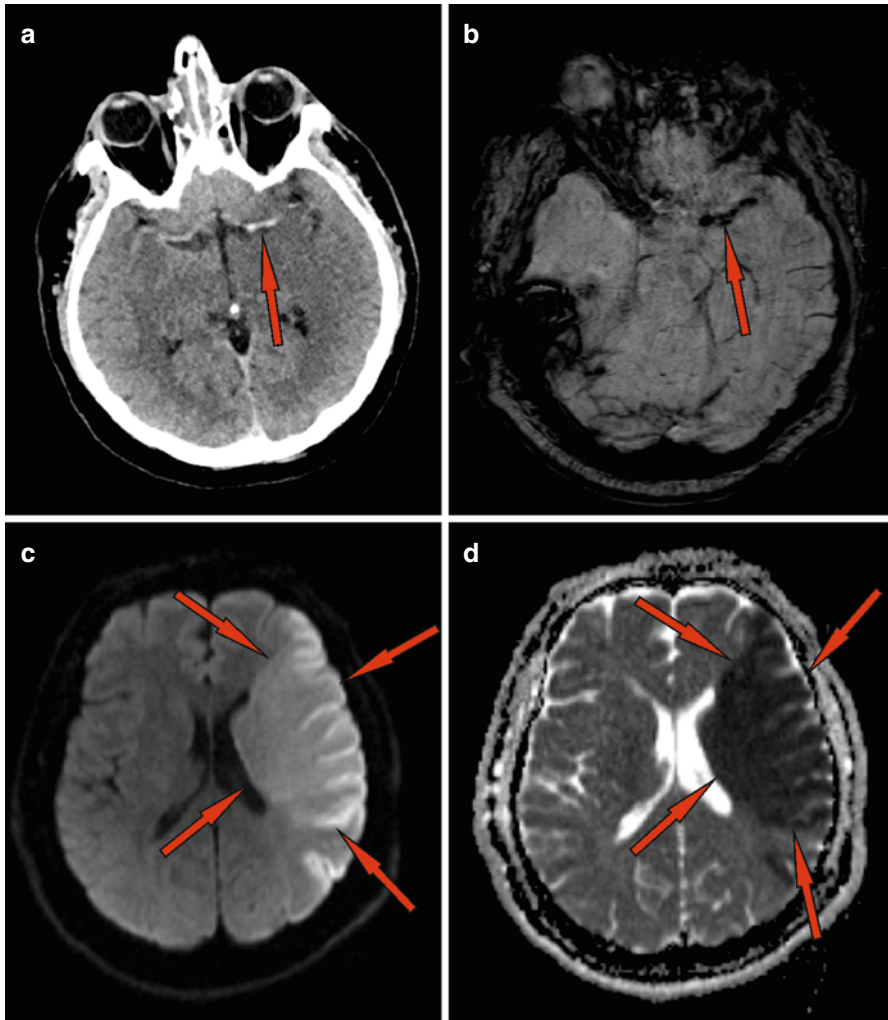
CT and MRI imaging of a wide infarction in the left middle cerebral artery (MCA) territory (TACI stroke). CT scan (a) of the malignant left MCA (*red arrow*). MR SWI scan (b) of a clot (*red arrow*) in the left MCA with corresponding CT image. High-intensity signal in the left MCA territory (c) in DWI-MRI ($b = 1000$) sequence (*red arrows*) with corresponding DWI low-intensity signal in the ADC map (d) (*red arrows*)
